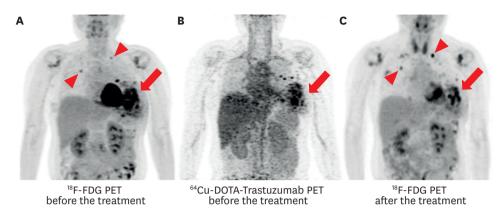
Maximum intensity projection images before and after the treatment. Recurrent lesions in the left breast (arrow) and a few pulmonary metastases (arrowheads) were observed on the ¹⁸F-FDG PET images. (A) ⁶⁴Cu-DOTAtrastuzumab PET images showed recurrent lesions in the left breast (arrow). (B) After the treatment, the ¹⁸F-FDG PET images show that while the extent and metabolic activity of the recurrent lesions in the left breast decreased (arrows), the size and metabolic activity of the metastatic lung lesions increased (arrowheads). (C) 64Cu-DOTAtrastuzumab PET image was obtained 48 hours after the ⁶⁴Cu-DOTA-trastuzumab injection.
